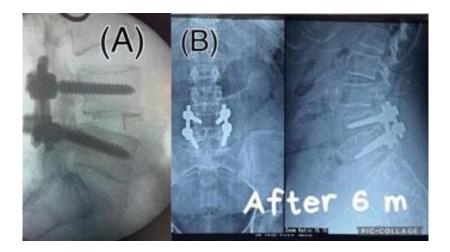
A- Postoperative x-rays demonstrating pedicle screw fixation with Polyether ether ketone (PEEK) interbody cage Lateral view. B- Postoperative follow up x-rays after 6 months demonstrating pedicle screw fixation with Polyether ether ketone
